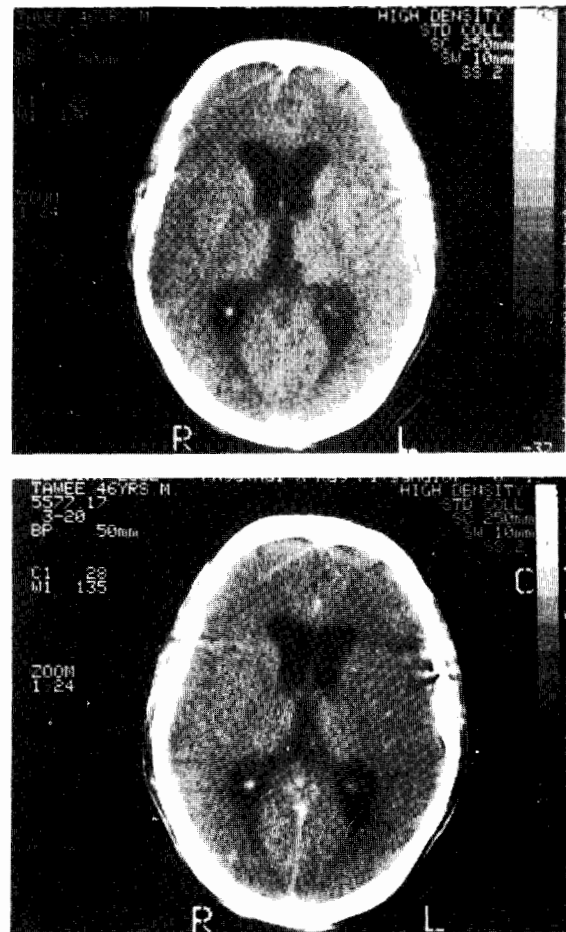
2 CT scan (pre and post contrast) showing dilated lateral ventricles.
